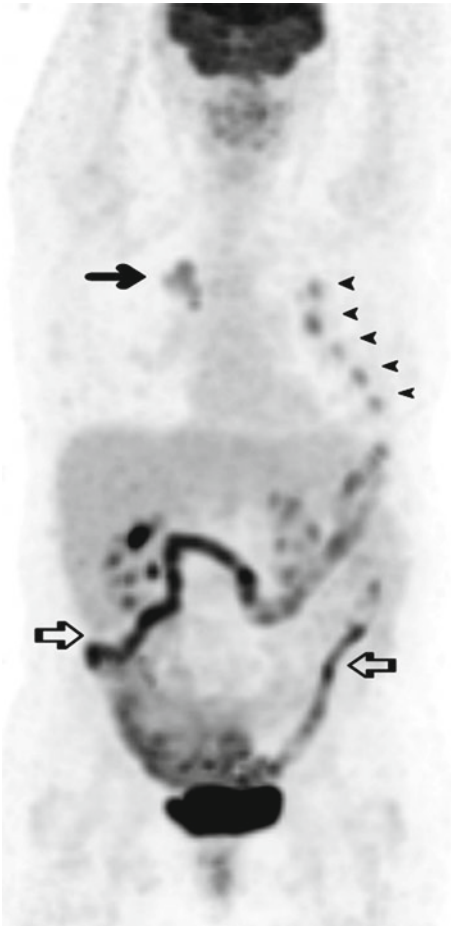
A 67-year-old woman presented for a FDG PET scan to further characterise an irregular 37 mm pulmonary mass in the upper lobe of the right lung. On PET the mass demonstrated moderately increased FDG accumulation (*arrow*) as well as adjacent focal uptake at the right pulmonary hilum consistent with primary lung cancer with ipsilateral hilar lymph node metastasis. There were multiple foci of increased uptake at the left second to sixth ribs anteriorly (*arrowheads*) in a consecutive pattern, some of which corresponded to callus formation on CT scan (not shown) consistent with rib fractures. Further history from the patient revealed recent trauma from an accidental fall onto her left side. There was also moderate to intense diffuse bowel uptake (*open arrows*) secondary to metformin therapy
